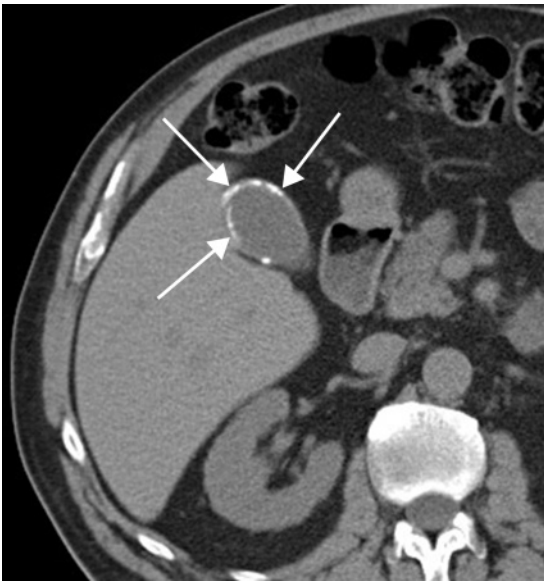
Porcelain gall bladder. Non-enhanced CT image demonstrates calcifications outlining the gall-bladder wall (arrows).
